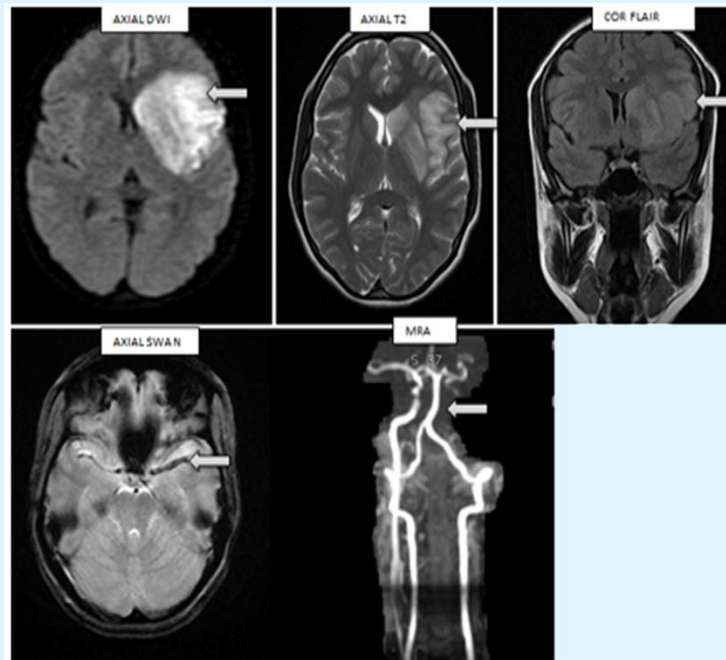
25 year old woman with 9 months of amenorrhea with right sided weakness, Axial DWI, T2, Coronal T2 FLAIR, SWAN and MRA shows left MCA territory infarct secondary to thrombosis involving left ICA and MCA.
